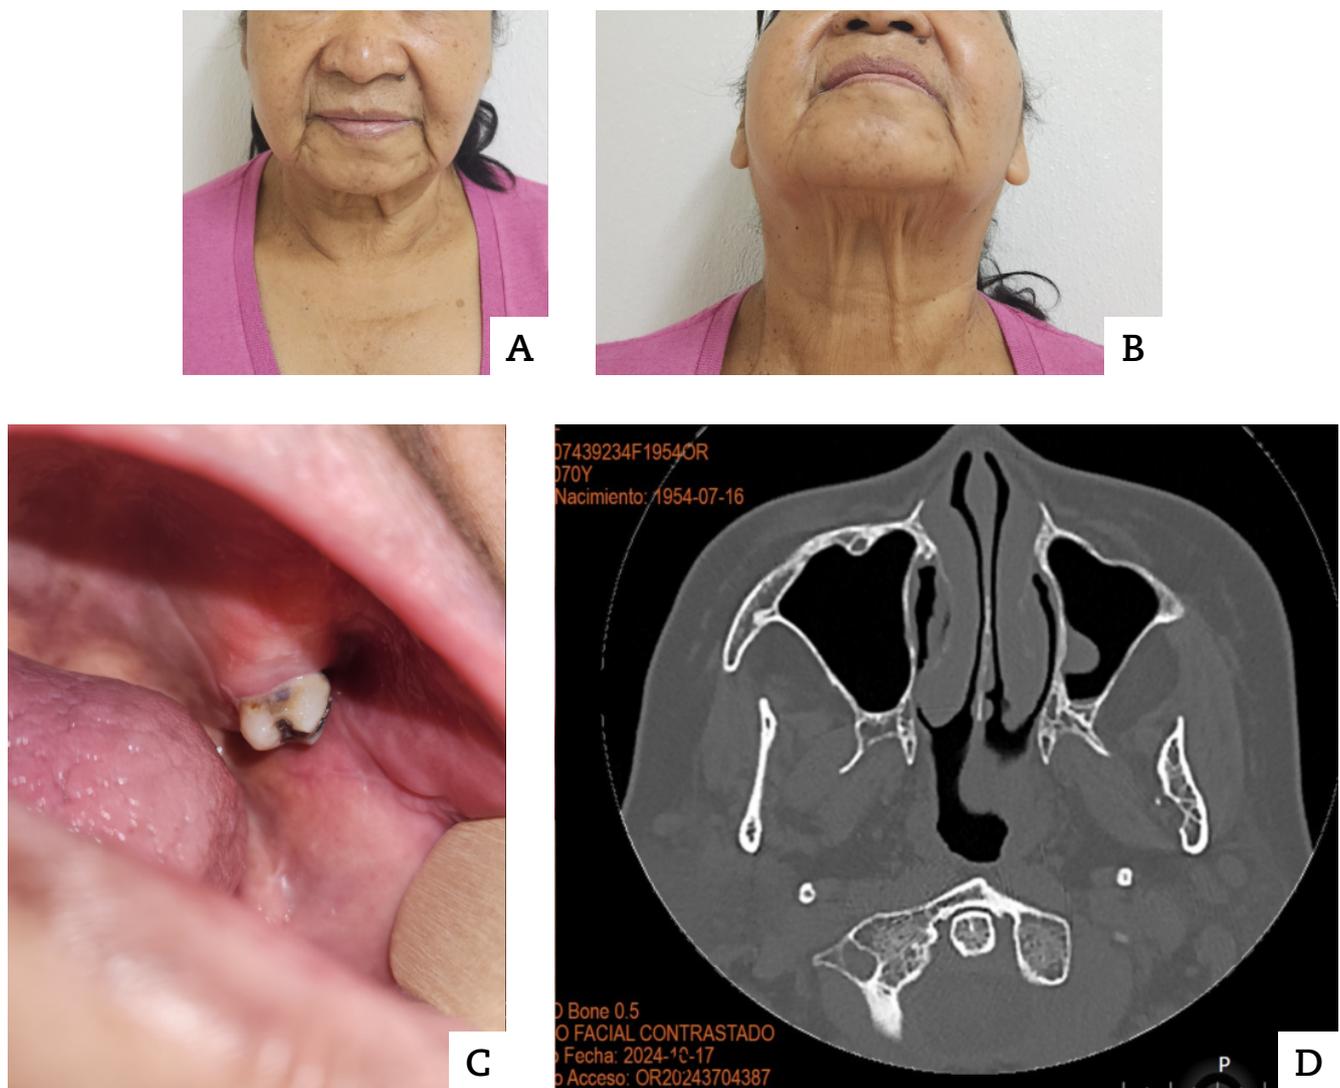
Post operative pictures of the patient showing a significant decrease in the volume of the left buccal region (A, B), left buccal mucosa completely healed after 2 months (C), Maxillofacial CT scan image after nineteen months showing no data of recurrence (D).
